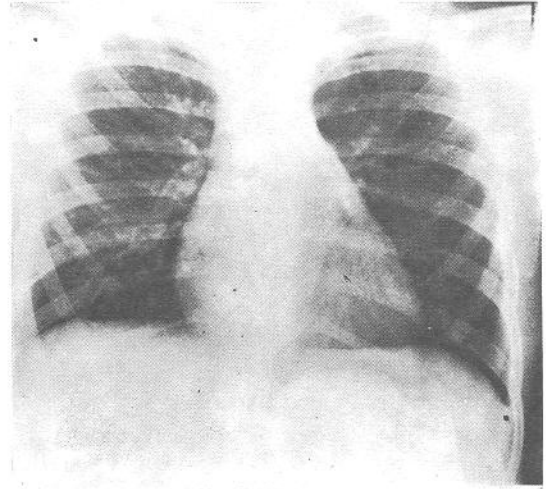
Chest radiograph two months after discharge shows further resolution with minimal residual right basilar streaky densities and right pleural reaction.
